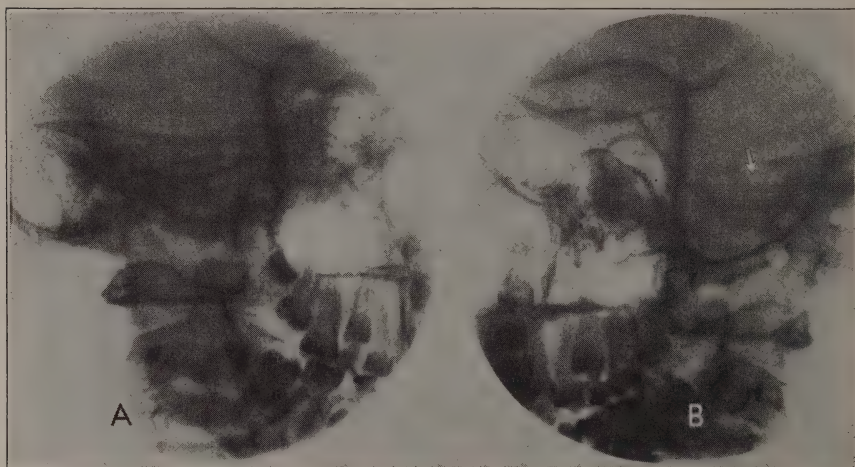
(Case 7). Roentgenogram taken before operation. The arrow indicates absence of the bony roof of the area of the apex tip. A granuloma was found plugging this area.
